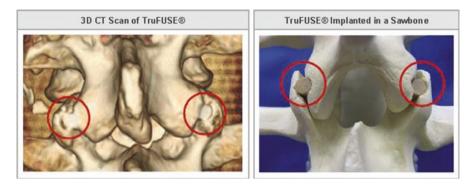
CT scan postoperative and anatomical model view
